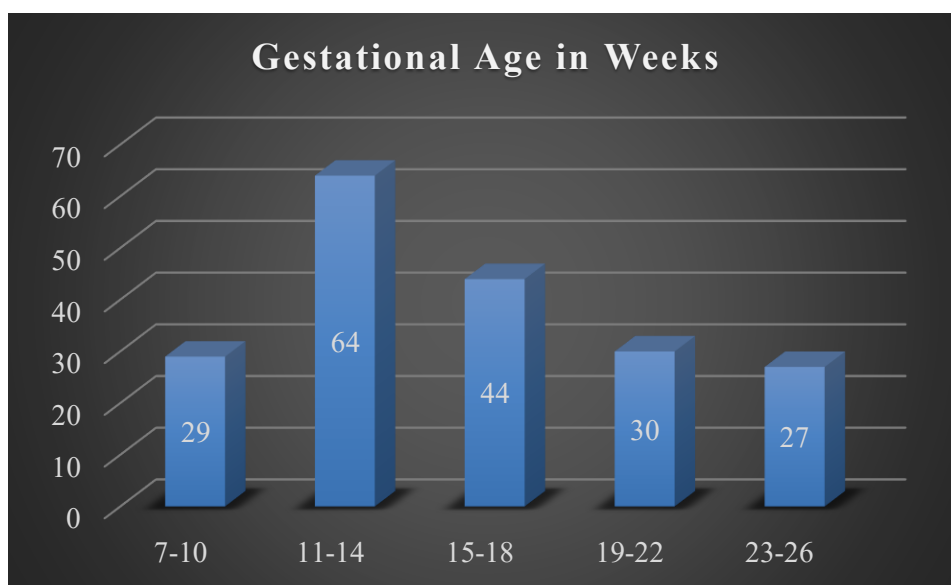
Range of ultrasound gestation for viable pregnancy (n=194)
